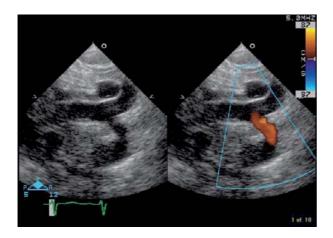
Suprasternal echocardiographic image of the aortic arch reveals mild hypoplasia of the transverse aortic arch with flow reversal in the aortic arch
